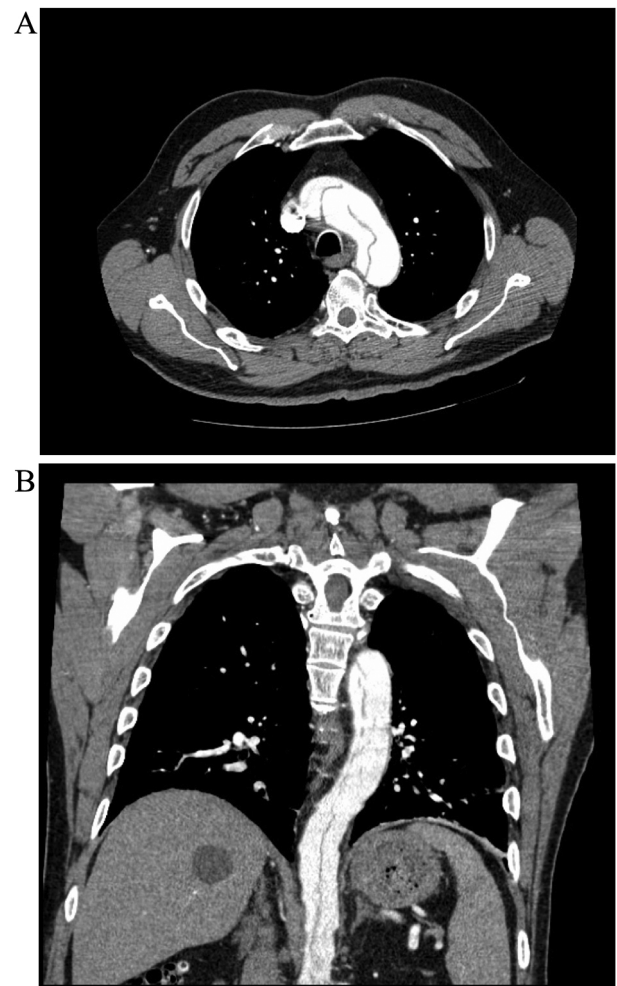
(A) CT slice of aortic arch with evidence of dissection flap. (B) Reconstructed coronal CT image of the chest with evidence of extensive antegrade extension of the aortic dissection.
